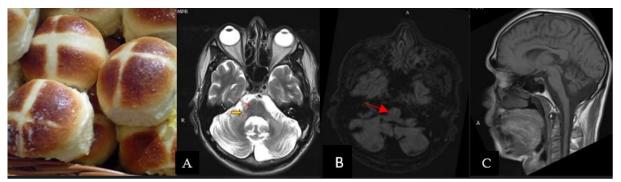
Cerebral MRI in an 83-year-old patient with clinical suspicion of SMA shows a harmonious widening of the bilateral cerebellar cortical sulcus, vermian prominence, pontine and middle cerebellar peduncles atrophy (A, solid arrow) describing a cross shaped hyper intensity on T2 sequences (A) more marked on SWI sequence (B, arrow) creating the aspect of the "HOT CROSS BUN SIGN" (arrow). On the sagittal T1 section (C) we note pontocerebellar atrophy with preservation of the size of the midbrain, consistent with an AMS-c.
